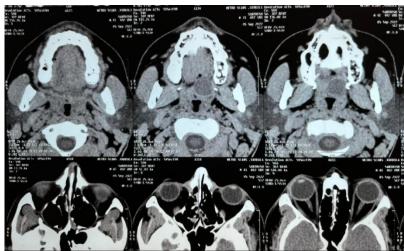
Axial section of CT PNS showing well defined homogenous fluid density cyst of 1.6 x 1.8 x 1.5 cm (CC x transverse x AP) in left side arising from anterior portion of soft palate with rim enhancement
